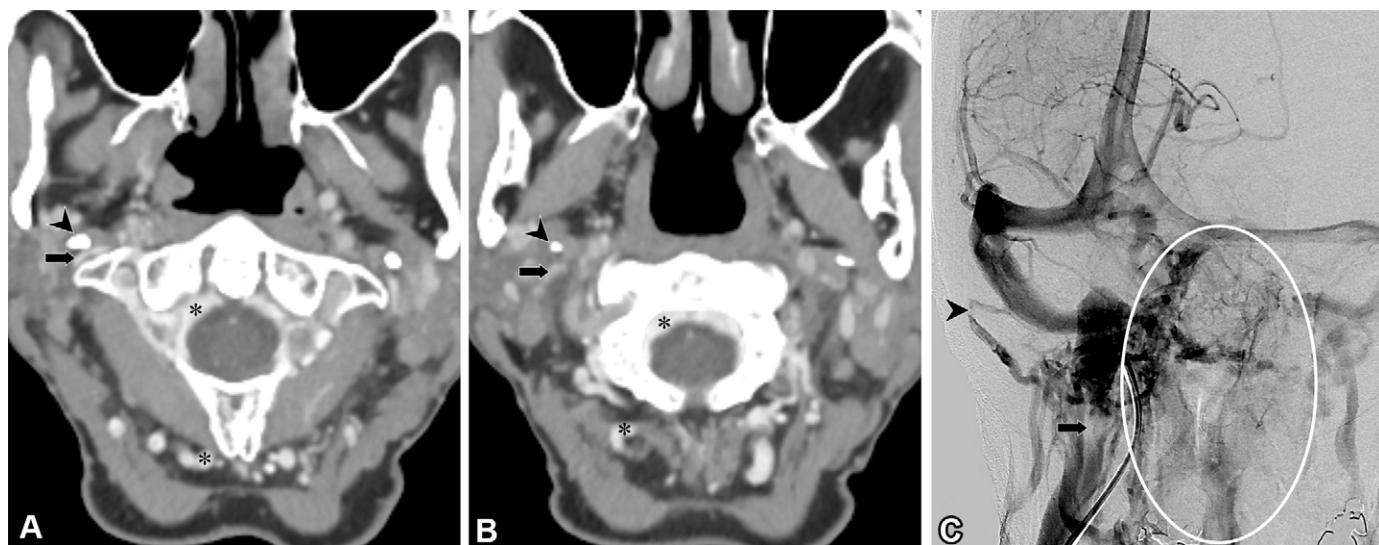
Vascular Eagle syndrome in a 66-year-old patient with right pulsatile tinnitus. (A, B) Axial CT angiograms show effacement of the internal jugular vein (arrow) between the styloid process (arrowhead) and C1 transverse process. The vertebral venous plexus and deep cervical veins (*) are of higher attenuation than both internal jugular veins. The patient underwent DSA. (C) Right internal carotid angiogram in the venous phase of enhancement shows effacement of the internal jugular vein at the level of the C1 transverse process (arrow). Most of the contrast material is seen draining across condylar collaterals, a prominent mastoid emissary vein (arrowhead), and the vertebral venous plexus (oval), consistent with vascular Eagle syndrome. The patient was counseled and opted for conservative management.
